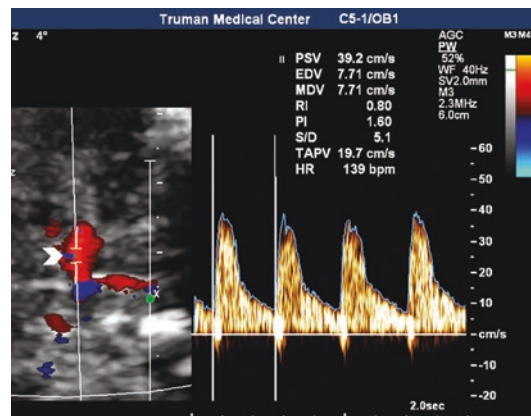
Hemodynamic assessment of the fetal middle cerebral artery. Left: Color Doppler imaging shows middle cerebral artery flow and spectral Doppler interrogation. Right: Spectral Doppler flow waveforms from the artery. White arrow shows the location of the Doppler interrogation
